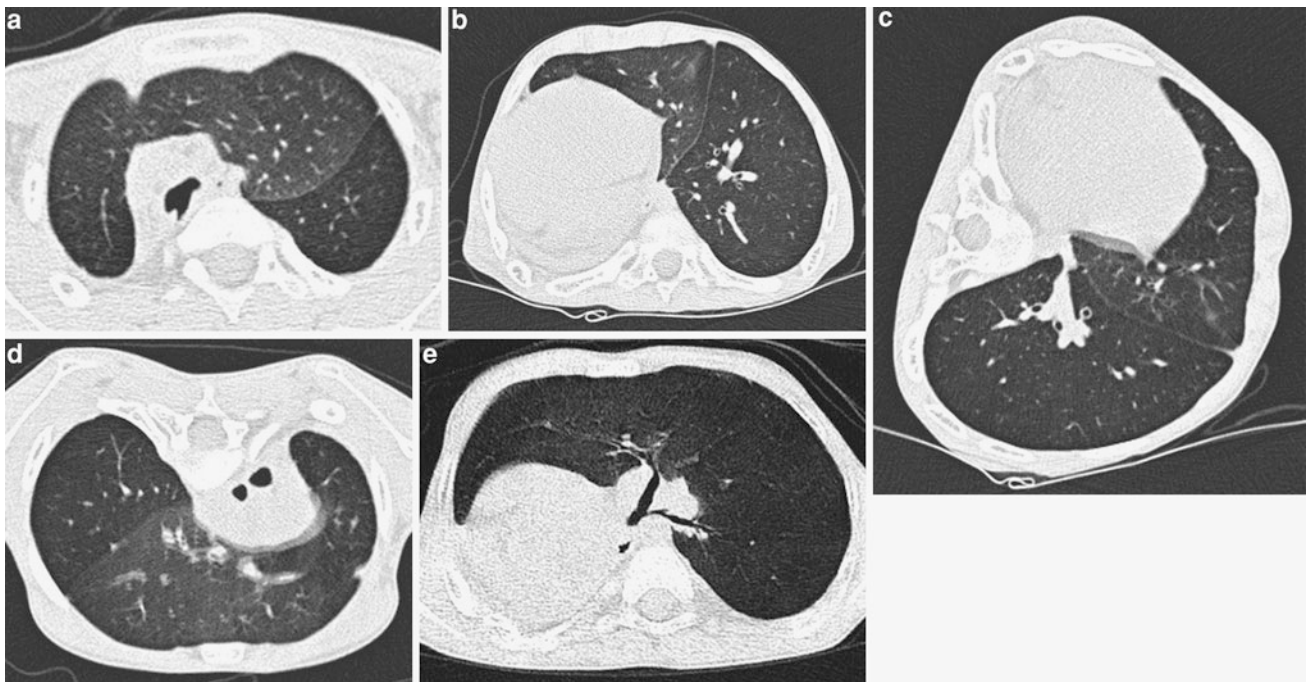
HRCT in a 23-day-old baby with meconial aspiration and sepsis. Supine scan (a) shows a ground-glass opacity in the left lower lobe, which persists in the right lateral decubitus scan (b)
